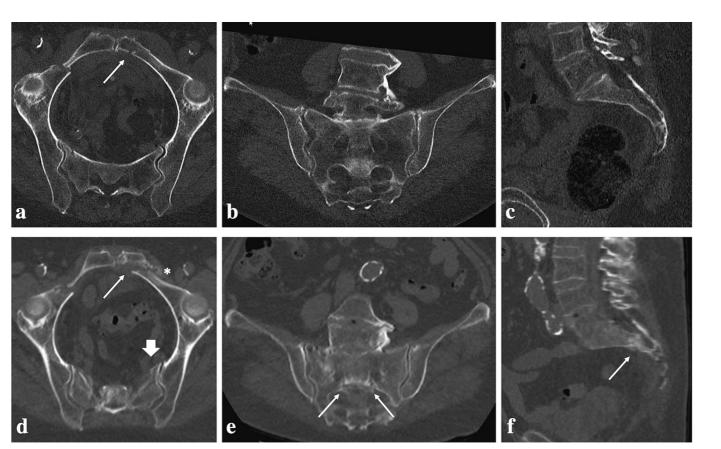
Reconstructions of initial and follow-up preoperative CT imaging in the (a/d) transverse, (b/e) coronal, and (c/f) sagittal plane showing fracture progression from FFP IIb to FFP IVb within one month. In the transverse plane, signs of crescendo instability are secondary dislocation of the anterior pelvic ring (arrows) despite callus formation (*), and an additional fracture line at the left sacral ala at follow-up study (big arrow in d). In coronal and sagittal planes, the transverse fracture component is visible at follow-up studies (arrows).
